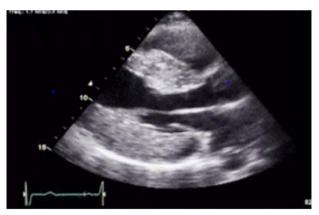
Echocardiogram of a patient with Hypertrophic Obstructive Cardiomyopathy with Dynamic Left Ventricular Outflow Tract (LVOT) obstruction
